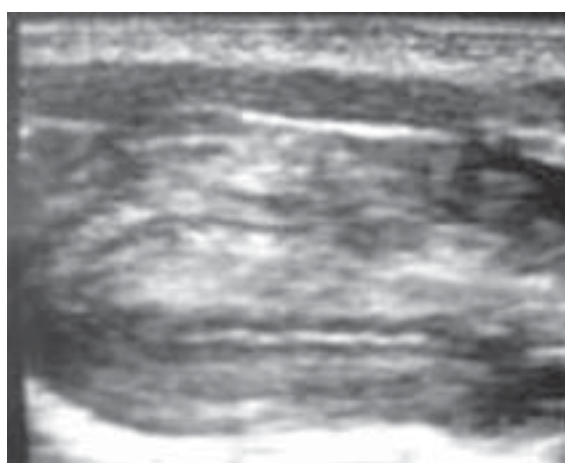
Sagittal ultrasound scan of the neonatal uterus after drainage
